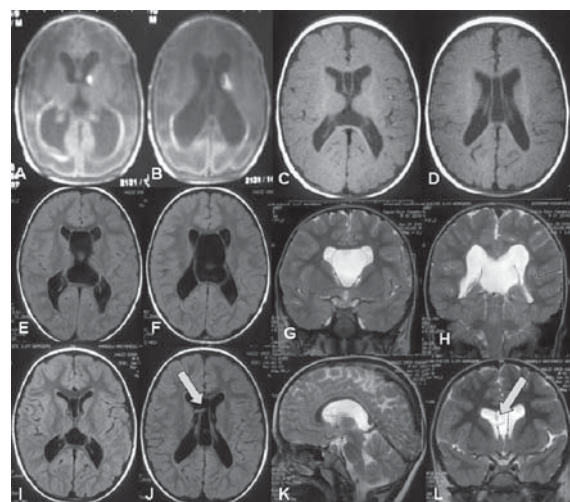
Brain MRI of our case in different life periods demonstrating progressive expansion of the cyst and the postoperative results. A-B: The first MRI during follow-up in the neonatal ICU showing the resolved IVH and formation of CV. C-D: The second MRI at the age of 1 year showing the classical CV with minimal expansion compared to the first imagings. E-H: The third MRI at the age of 3.5 years showing the massive expansion of CV compressing the lateral ventricles bilaterally. I-L: Postoperative MRI 1 year after the operation showing regression of CV, decompression of the lateral ventricles and the communication of CSF flow between the cyst and the lateral ventricles (arrows).
